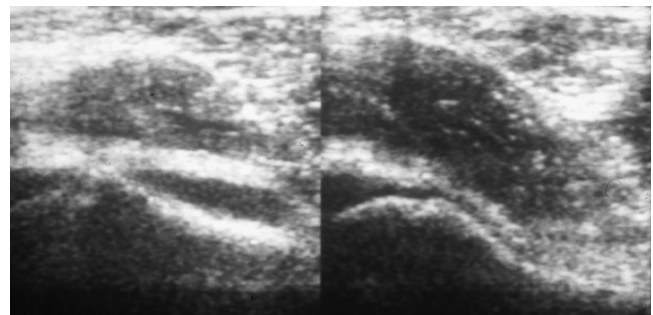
Ultrasonography of patient in Figure 2 detects effusion and slip of left hip (right side of image). The right side (left half of image) shows neither slip nor effusion.
